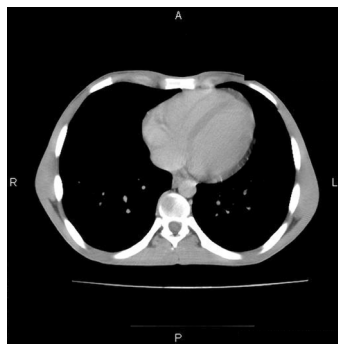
Thoracic CT+C – transversal scan plan: Anterior and superior diffuse hypodense bone image in T9 vertebral body.
